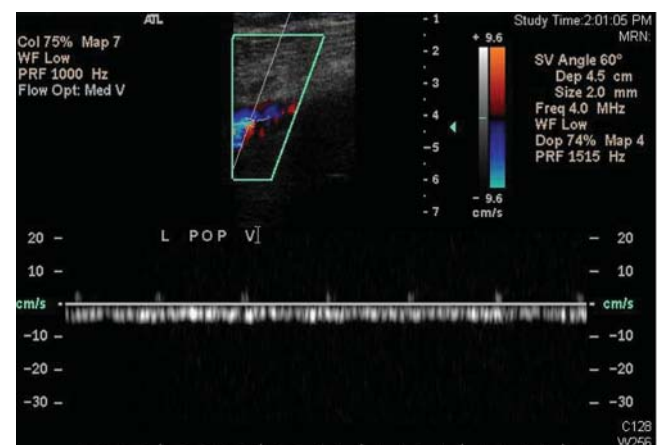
An ultrasound demonstrating a normal venous flow pattern within the popliteal vein.
